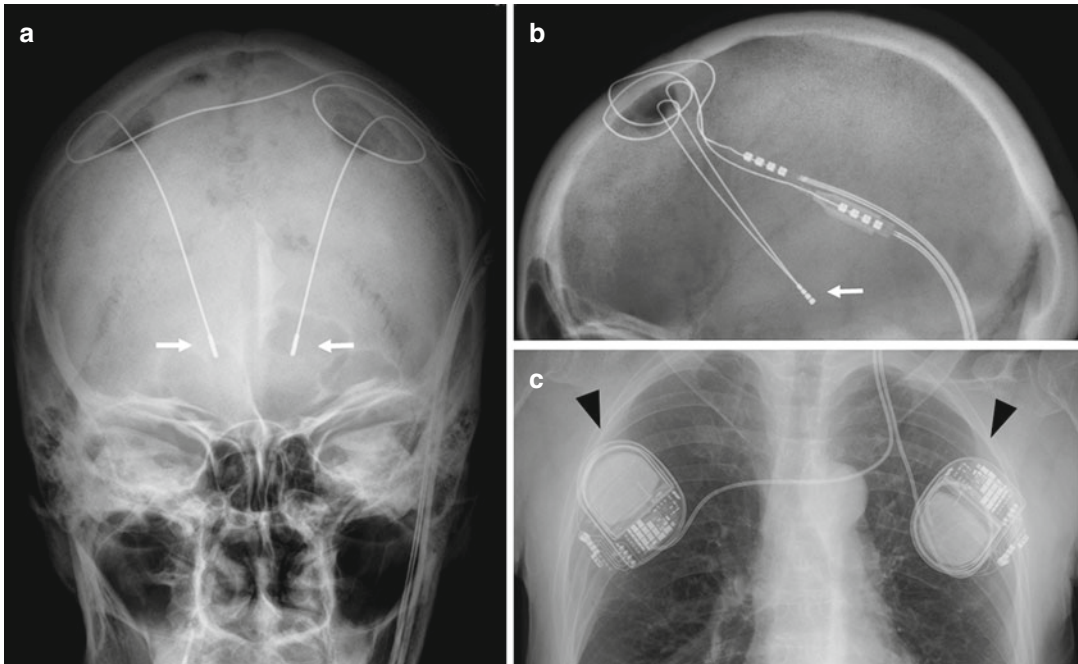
Postoperative radiograph example of subthalamic deep brain stimulation (STN-DBS). (a, b) Skull X-ray demonstrates electrode leads for STN-DBS (white
